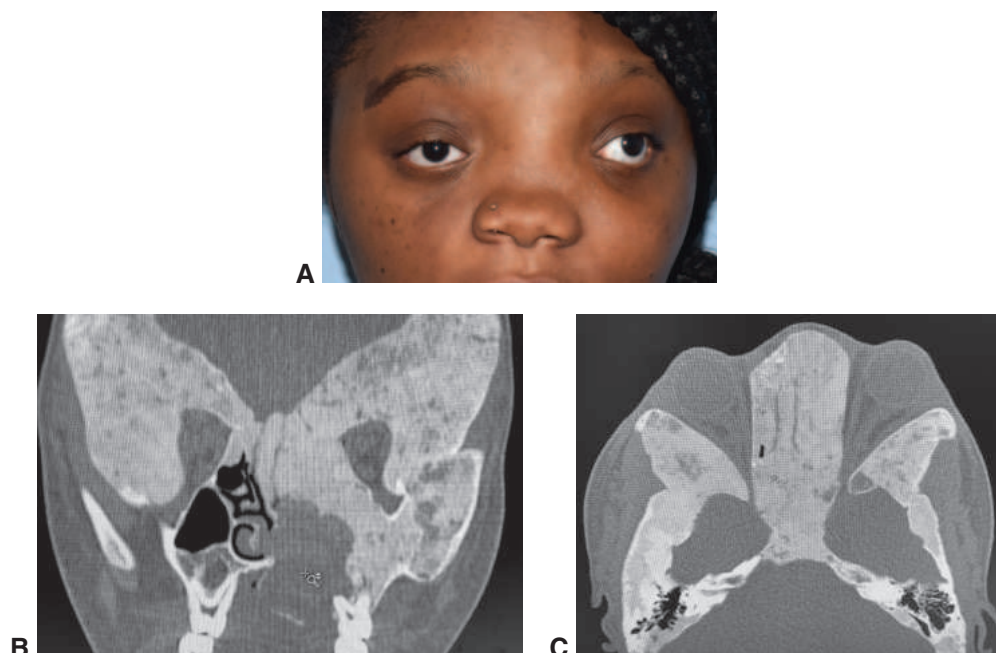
Fibrous dysplasia/McCune-Albright syndrome. A, Facial asymmetry. B–C, Coronal and axial CT scans demonstrate characteristic hyperostosis of involved facial bones. (Courtesy of William R. Katowitz, MD.)
